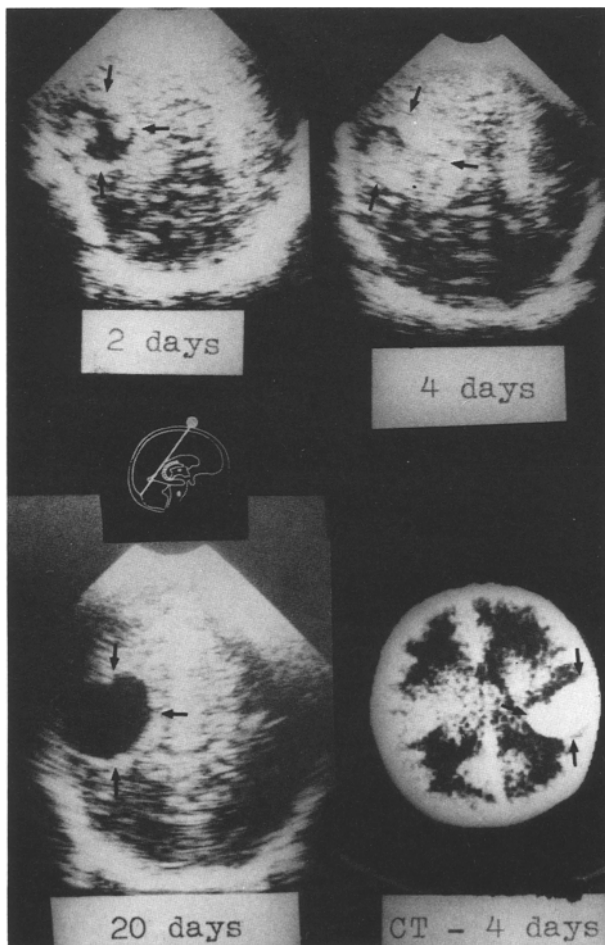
Patient 3. Ultrasound: left sided horseshoe-shaped area of decreased echos (day 2) with increasing echos at its border (day 4). Development of a porencephalic defect (day 20). Computed tomography (day 4): fresh hematoma in the same area
